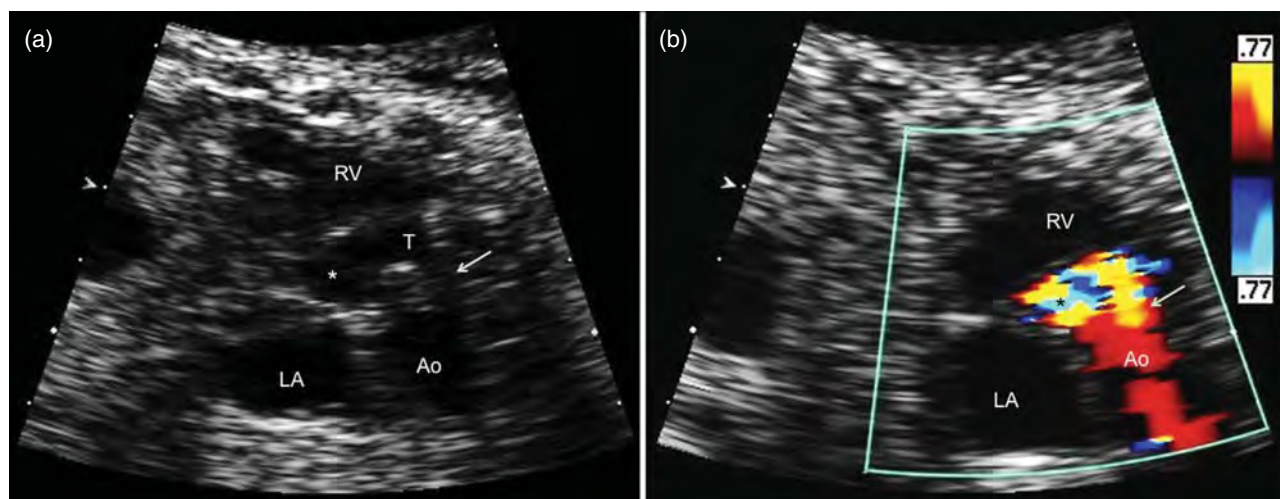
These images were taken during a prenatal echocardiogram performed because the fetus was thought to have truncus arteriosus with truncal valve regurgitation. The images oriented similar to parasternal long-axis transthoracic echocardiographic images. There was a normal pulmonary valve and no ventricular septal defect, eliminating truncus arteriosus as a possible diagnosis. (a) An extracardiac, paravalvar connection between the ascending aorta (Ao) and the left ventricular outflow tract (white asterisk), confirming the presence of an aorto-left ventricular tunnel (AoLVT). (b) Color flow Doppler imaging revealed not only significant diastolic flow through the AoLVT (arrow), but also aortic valve regurgitation (black asterisk). Despite the combination of these two abnormalities, the fetus did not develop hydrops. He did require neonatal repair of both the AoLVT and the aortic valve with eventual aortic valve replacement later in childhood. He continues to do well postoperatively. LA, left atrium; RV, right ventricle; T, aorto-ventricular tunnel.
